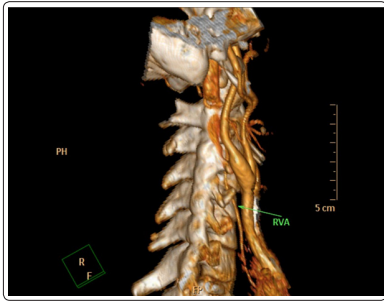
CTA image of hypoplastic right VA
